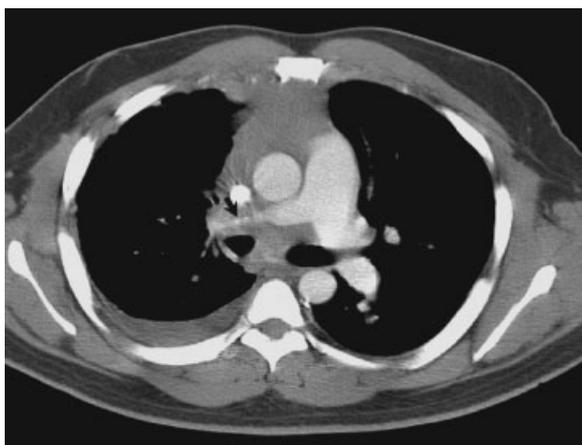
This 34-year-old male had respiratory symptoms prompting a chest x-ray. A small effusion was noted and a chest computed tomographic (CT) scan was obtained. The patient had minimal dyspnea on exertion. The chest CT showed marked narrowing of the right pulmonary artery (arrow) with increased mediastinal soft tissue density and some distortion of the right mainstem bronchus. Immunodiffusion showed a positive M band and a yeast complement fixation titer of 1:8. No therapy was instituted and he was diagnosed with fibrosing mediastinitis.
